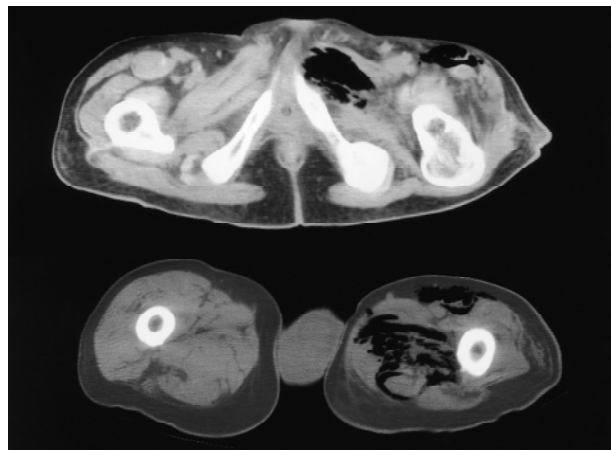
Selected images from computed tomography of the lower abdomen and the left thigh, showing edematous tissue with crepitation and multiple bullae.
